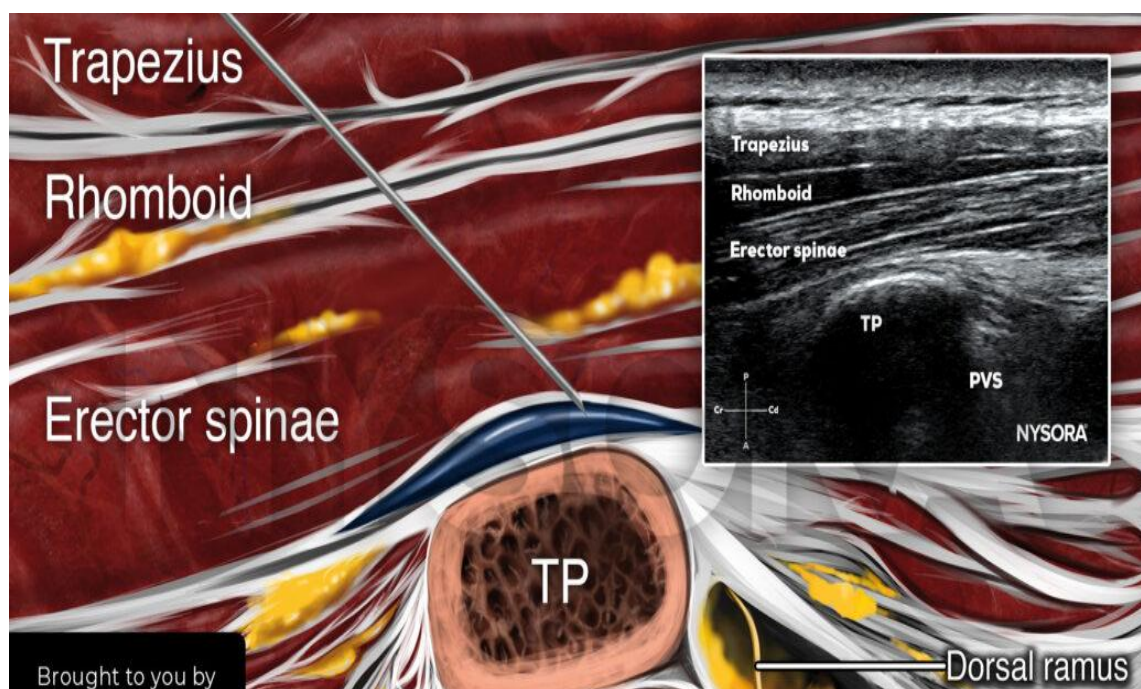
Ultrasound guided image of Erector spinae muscles
